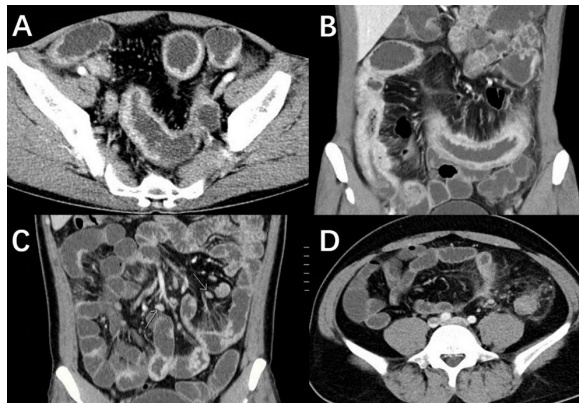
The typical radiographic appearance of CD: (A) thickening and enhancement of the intestinal wall, (B) the "comb sign" of CD, (C) enlarged lymph nodes around the bowel, (D) fibroadipose hyperplasia.
